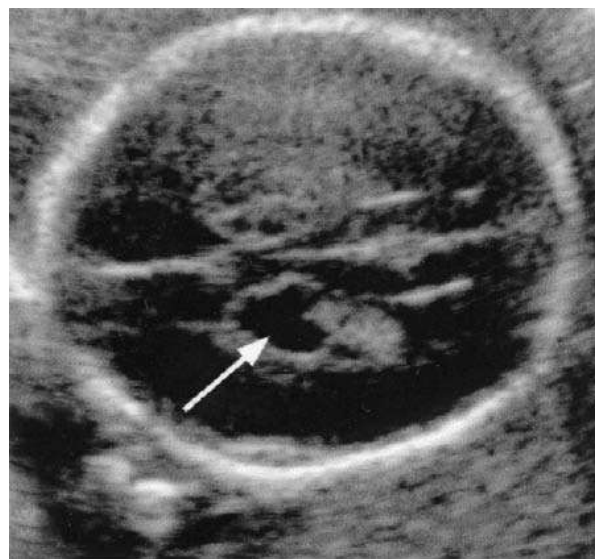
Choroid plexus cyst. This axial image demonstrates the sonographic appearance of a choroid plexus cyst (arrow) (Ash Monga et al, 2011)
